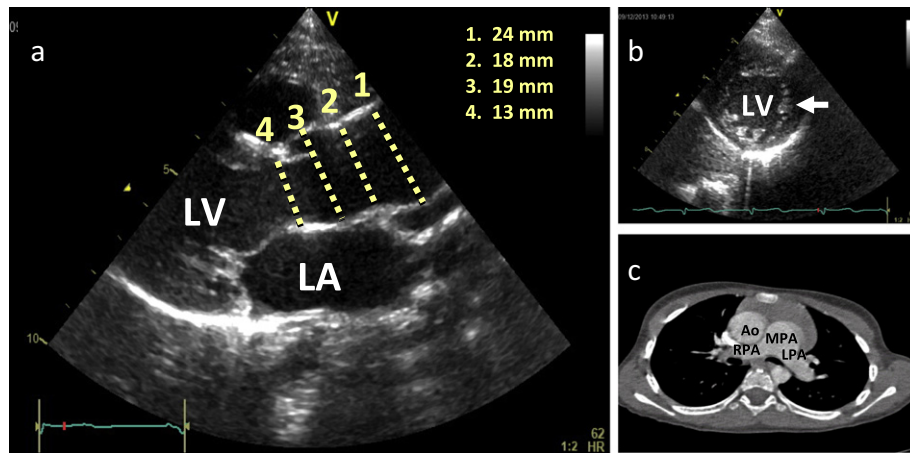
Echocardiogram and cardiac CT images of the proband. a. High parasternal echocardiographic long axis view showing the diameters of the proximal aorta with clearly dilated ascending aorta. LA: left atrium, LV: left ventricle. b. Echocardiographic short axis view of the left ventricular apex showing the prominent trabeculations and deep recesses of the non-compacted endocardial layer (arrow). c. Computed tomography scan of the chest (axial view) showing the dilated ascending aorta (Ao), main pulmonary artery (MPA), left and right pulmonary arteries (LPA and RPA).
